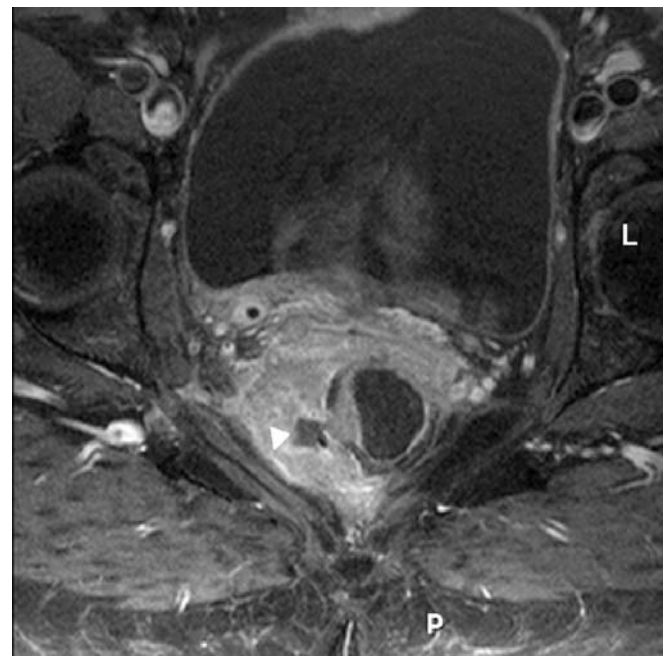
Recurrent rectal cancer. Paraxial T1-weighted SE sequence with fat suppression after i.v. application of gadopentetate-dimeglumine at a dosage of 0.2 mmol/kg body weight. The large extraluminal tumor shows central necrosis (arrowhead) and reaches the right pelvic wall
